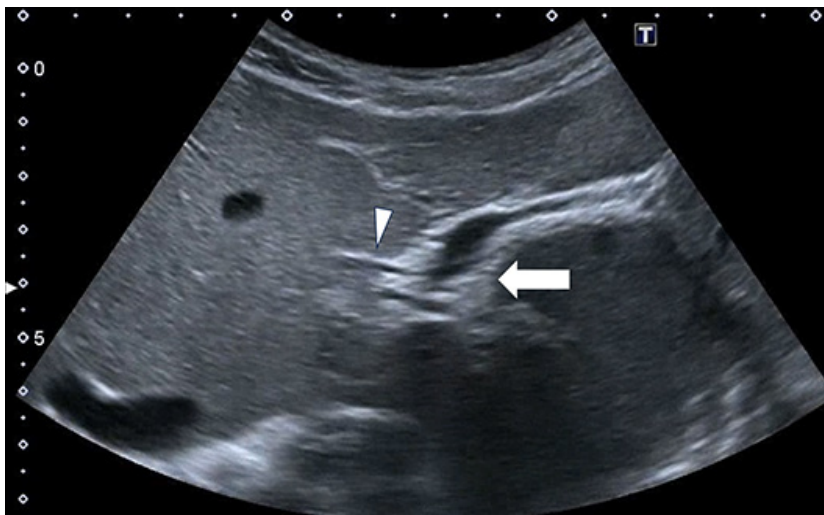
Sonographic Image Displaying Periductal Fibrosis Characterized by Increased Periportal Echogenicity (arrow), which often Accompanied by Borderline Bile Duct Dilatation (arrowhead).
